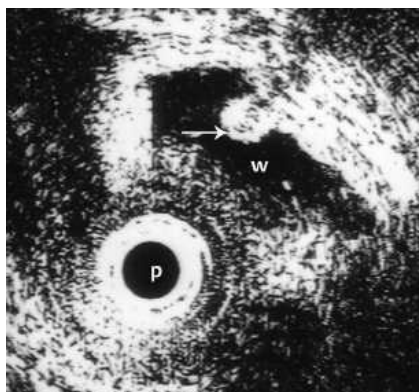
A small polyp in the bowel (arrow), water in the lumen (w), and ultrasound probe (p).
